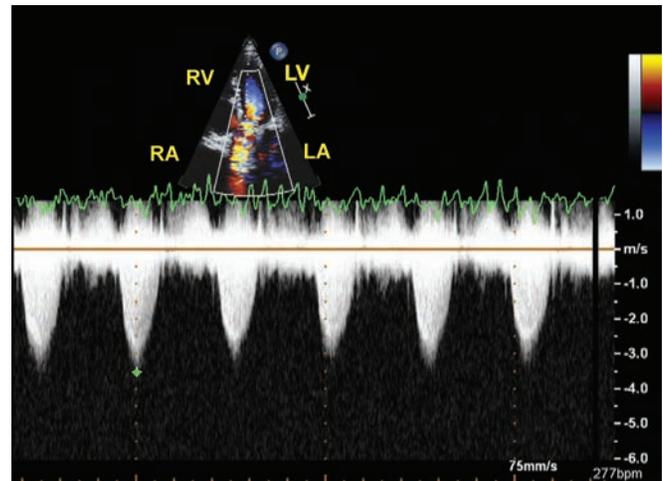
Continuous wave Doppler interrogation of LVOT reveals a high gradient of 50 mm Hg.
